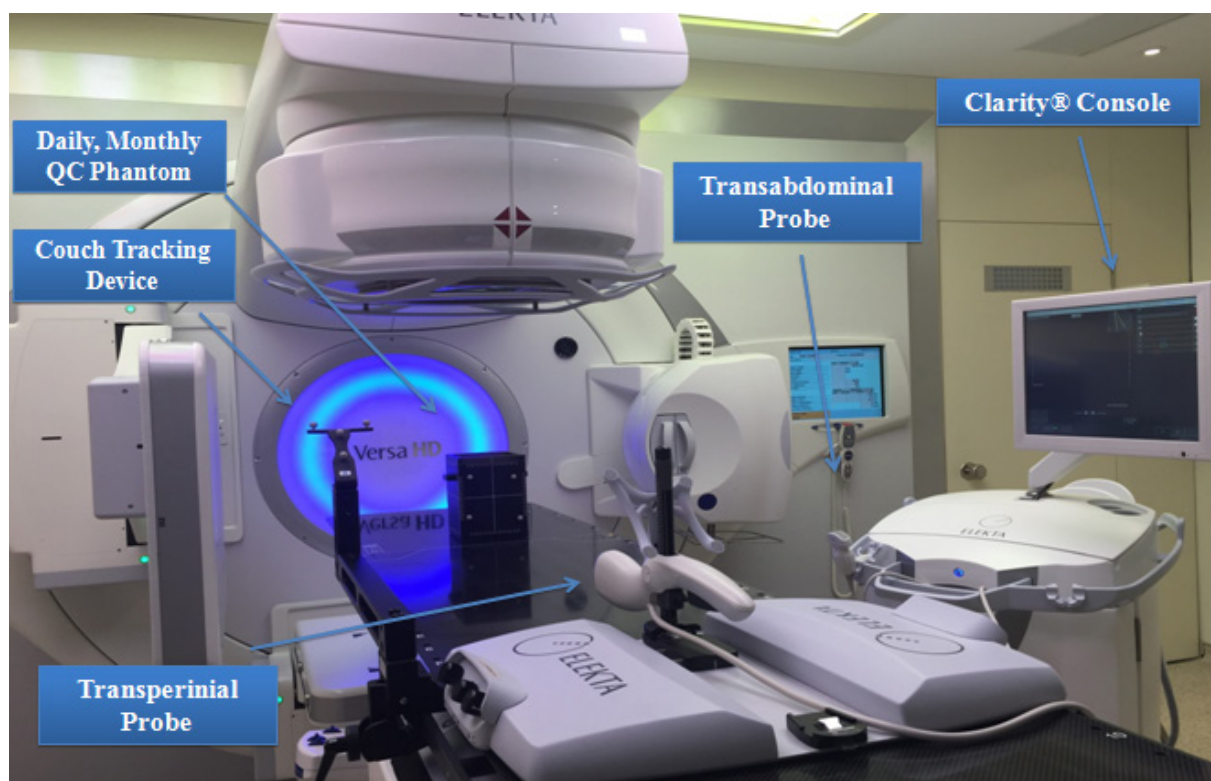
Elekta Versa HD[®] and Clarity[®] Ultrasound System
